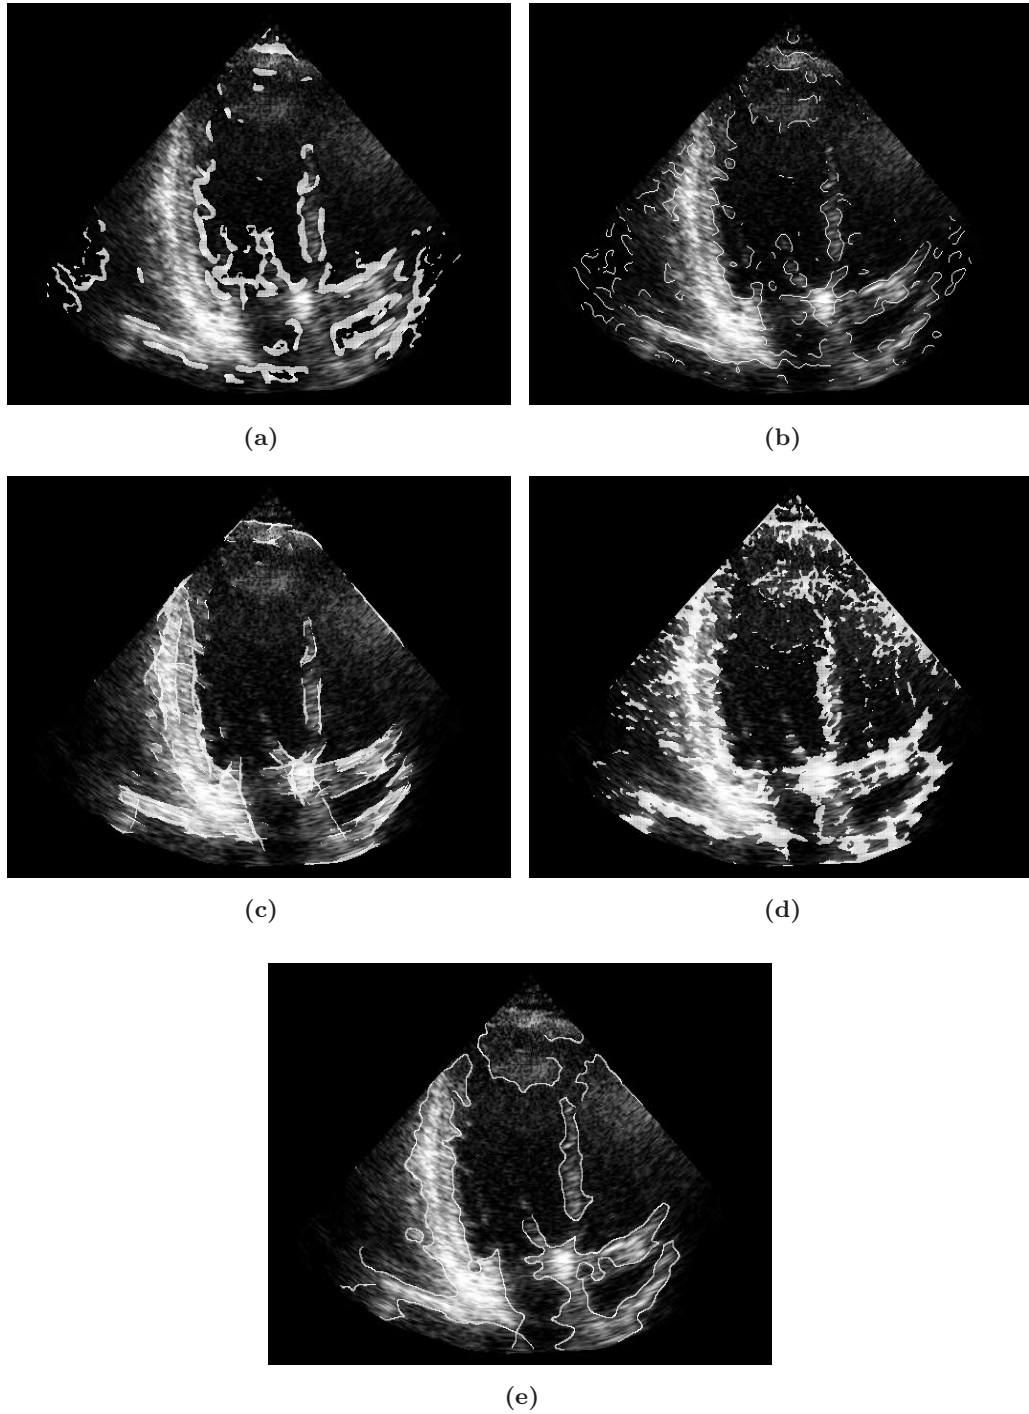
Edge detector output for the clinical ultrasound images of Fig. 6.7(d). (a) CV, (b) RoA, (c) FA, (d) PC, (e) ZC.
